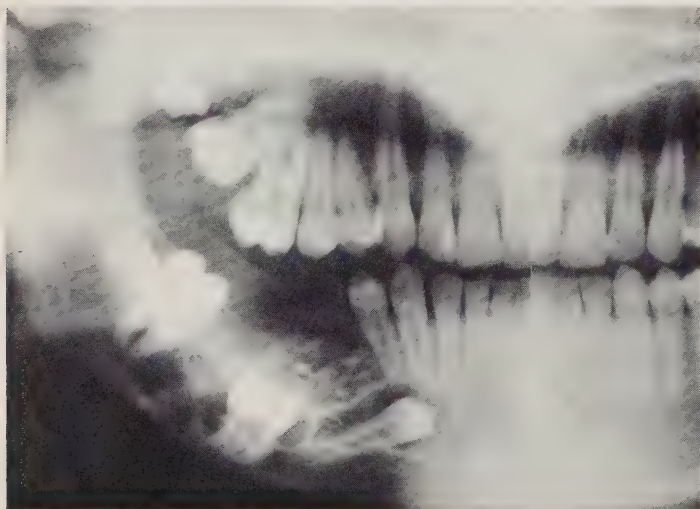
Panoramic x-ray of lesion in the right mandible.
